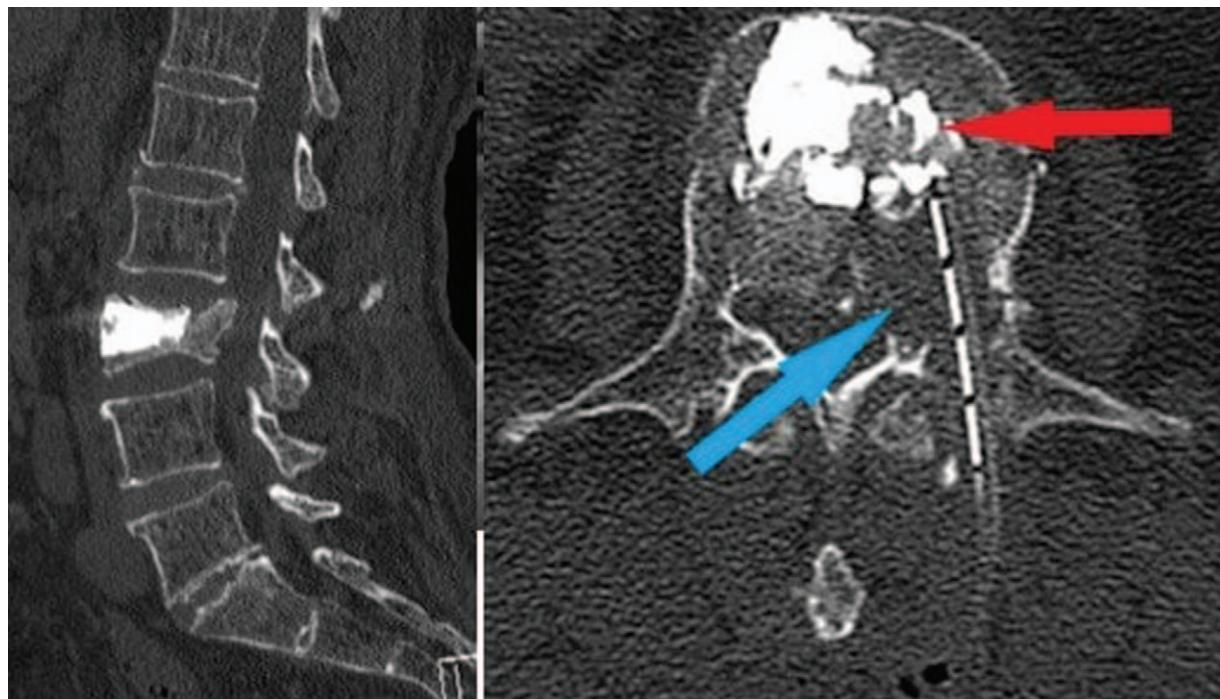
Postoperative CT blue arrow: Decompression zone, Red arrow: applied in cement.
